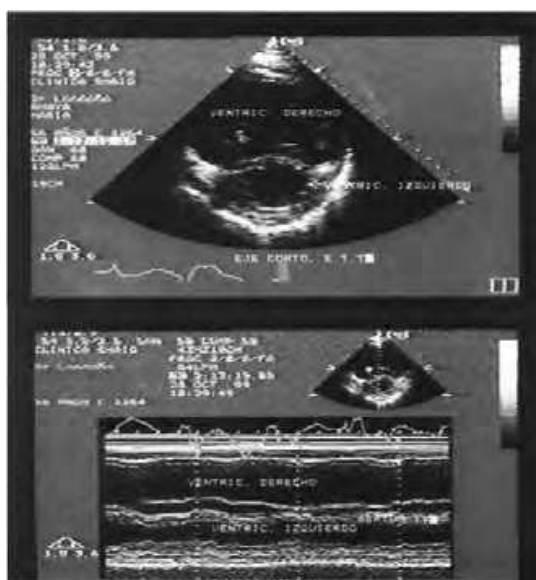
Echocardiography M mode (A) and bi-dimensional (B) of 54-year-old female with a history of aborted sudden death due to ventricular tachycardia) secondary to Chagasic cardiomyopathy. Note the severe dilatation of right ventricle. Fundación Clínica Abood Shaio, Bogota D.C., Colombia.
